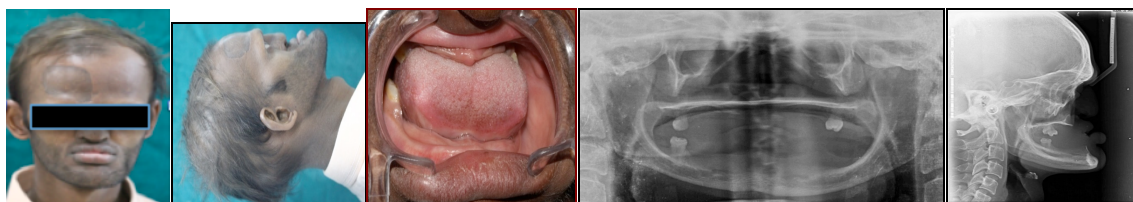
Clinical and radiographic images of patient
